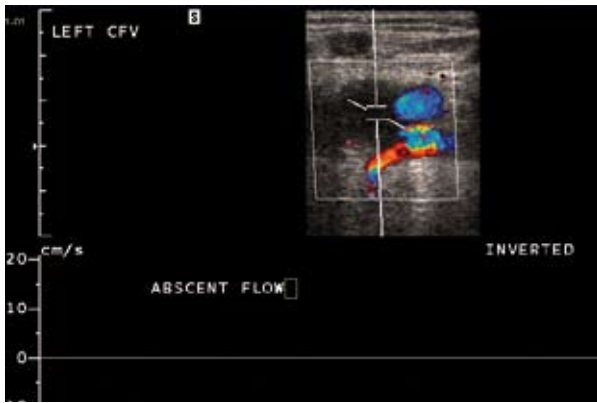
Doppler study shows a hypoechoic thrombus within the left common femoral vein, with non-compressible wall and absent flow.
